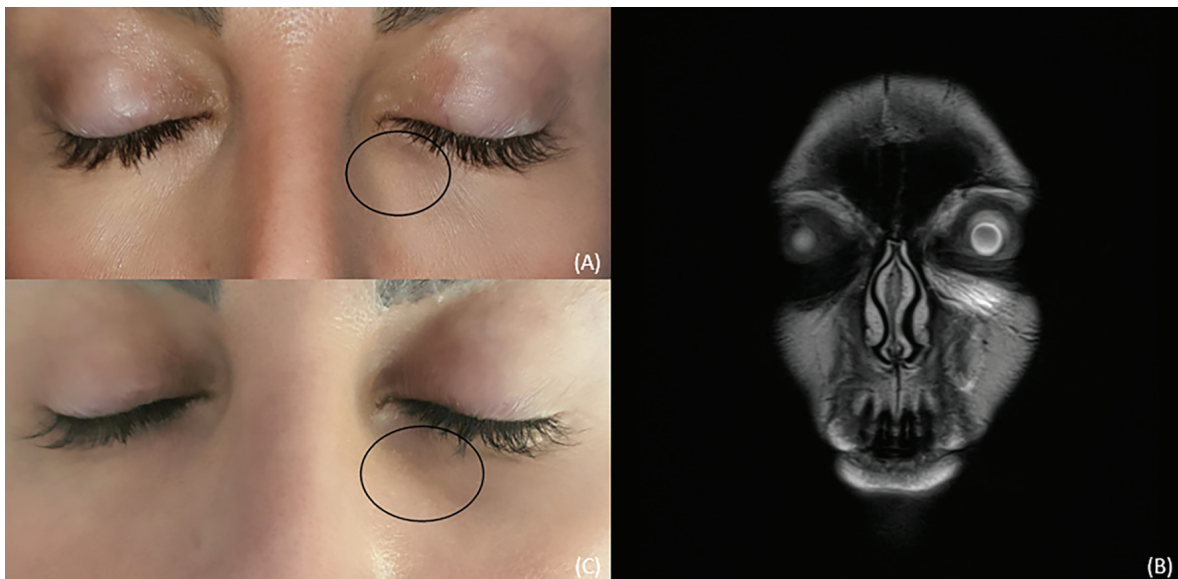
A) Left inferomedial orbital rim soft tissue involvement (circle). B) Post-contrast coronal T2-weighted magnetic resonance image demonstrating inferomedial diffuse contrast enhancement. C) Regression of soft tissue involvement 6 weeks after cortisone treatment
